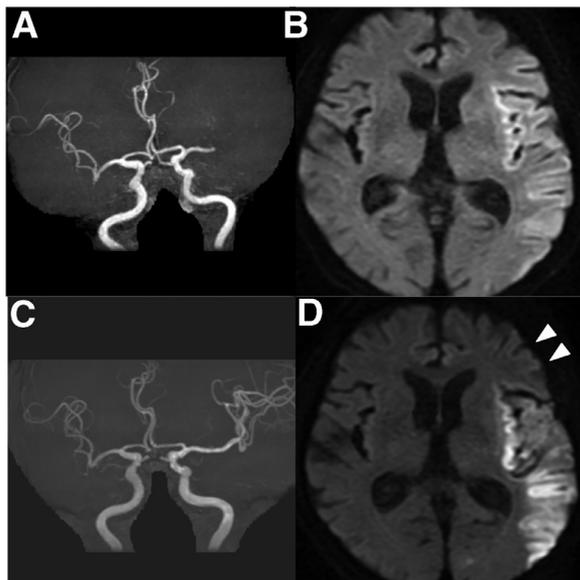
An 82-year-old man with cardioembolic stroke in the left middle cerebral artery territory (A). DWI shows a high intensity area in the left middle cerebral artery territory (B). Postoperative magnetic resonance angiography demonstrates complete revascularization of the left middle cerebral artery territory (C). Postoperative DWI shows disappearance of the high signal intensity area in the left frontal lobe (arrow) (D). DWI, diffusion-weighted imaging.
